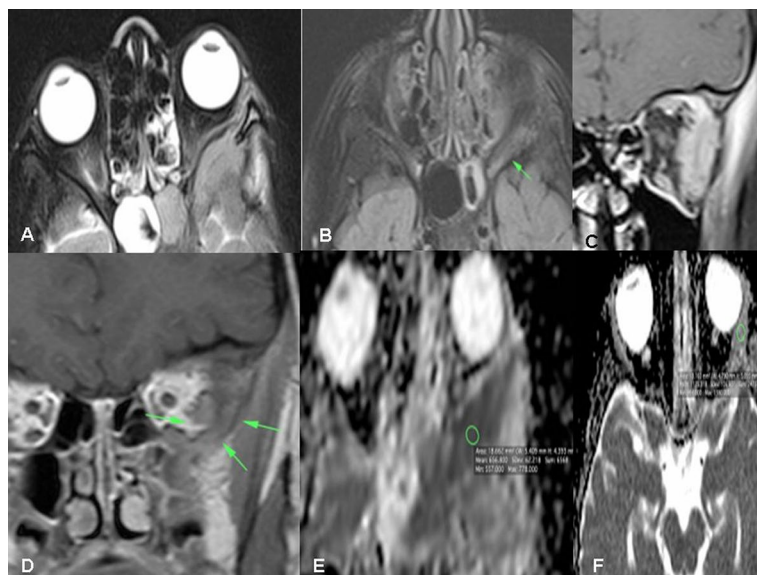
A 14-year-old male patient with history of rapid left-sided proptosis, swelling in the lateral aspect of the left orbit and dull aching left orbital pain. Initial orbital MRI with contrast was done. Axial T2-weighted image A shows hypointense infiltrative mass involving the left extraconal fat, the lateral bony wall, the left sphenoid bone and sinus, with left temporal epidural component. Axial FLAIR follow-up image B shows isointense signal with reduction in mass size and loss of its epidural component as compared to the initial MRI study. Coronal post-contrast T1-weighted image C shows an enhancing left lateral extraconal mass in the left orbit. Follow-up coronal post-contrast T1-weighted image D shows marked reduction in the mass size and enhancement. Evident diffusion restriction on DWI (b_{1000})/ADC (E, F). The ADC value of $1.12 \times 10^{-3} \text{mm}^2/\text{s}$. Pathologically proved left orbital extraconal infiltrative lymphoma
